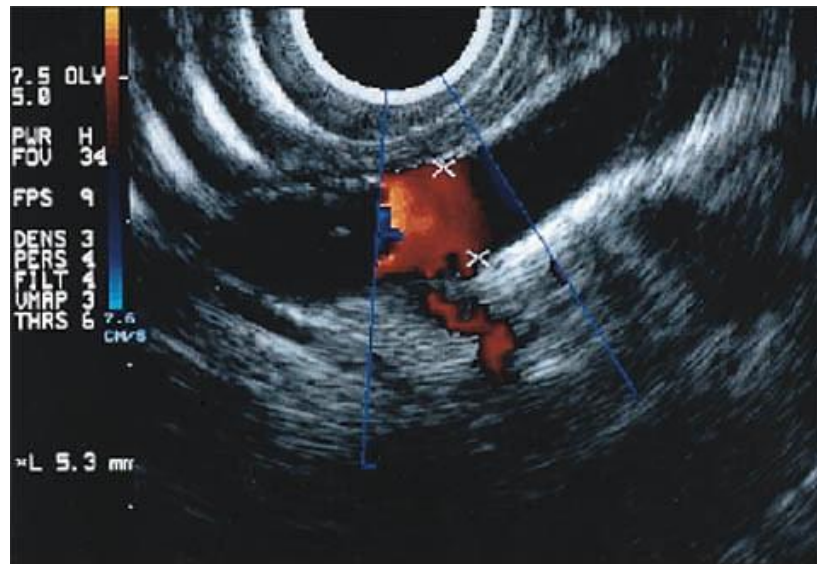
Azygos vein demonstrated by Doppler EUS. Red indicates cephalad blood flow
